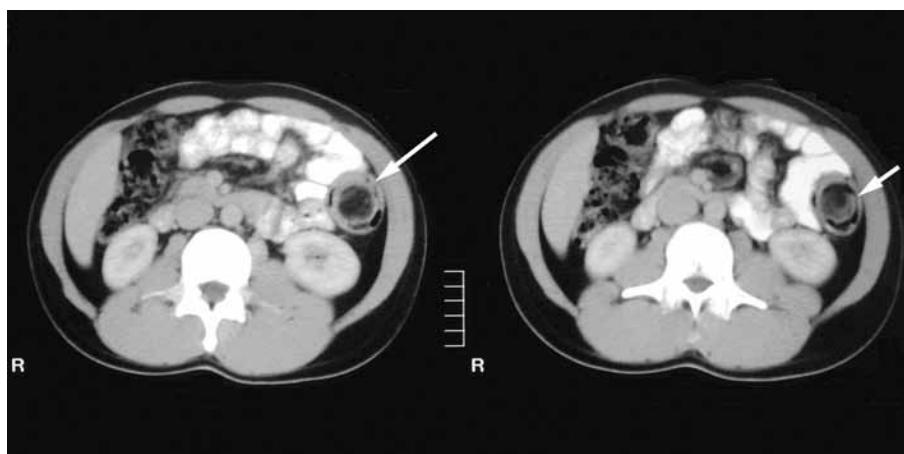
Abdominal CT scan revealed a round mass (arrows) within the lumen of the transverse colon; densitometric values consistent with a homogeneous fatty lesion establishing the diagnosis of lipoma of the colon.
